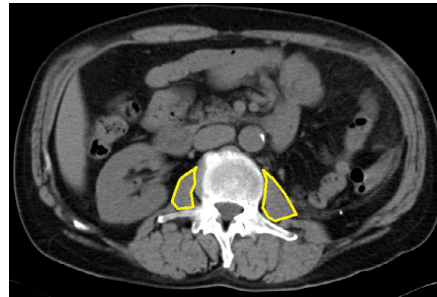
The area of the psoas measured on computed tomography images at the level of L3 is indicated in yellow
